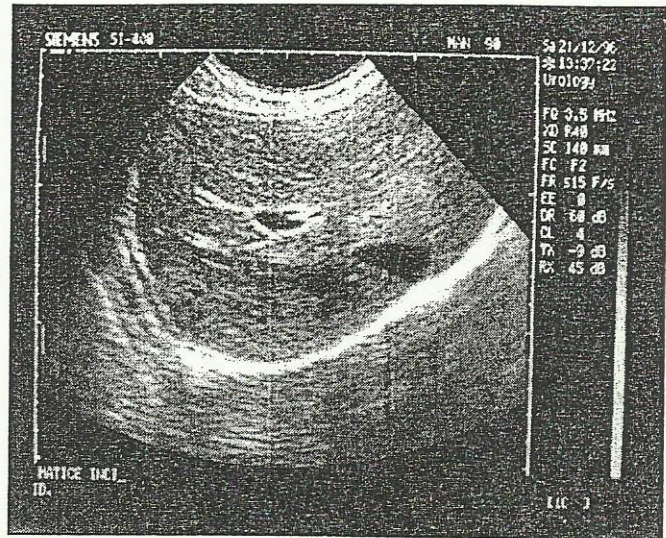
Ultrasonography of liver one month after percutaneous drainage.
